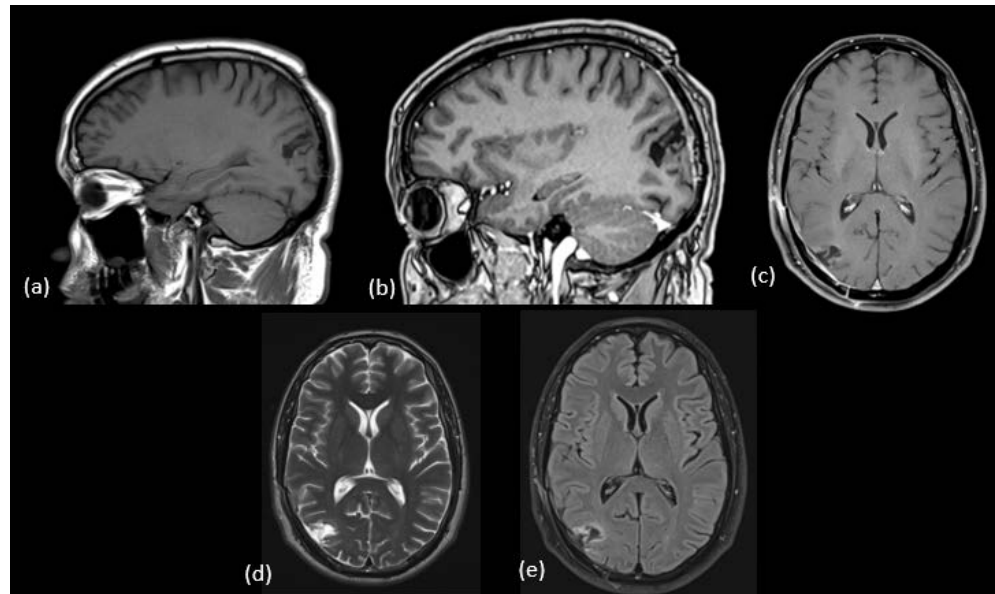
Postoperative sagittal T1-weighted (a), postcontrast sagittal T1-weighted (b) postcontrast T1-weighted axial (c) T2-weighted axial (d), and, axial flair (e) confirmed complete excision of the tumor.
